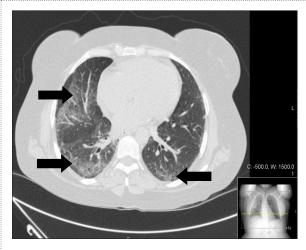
HRCT Chest showing interstitial changes (arrowed).
